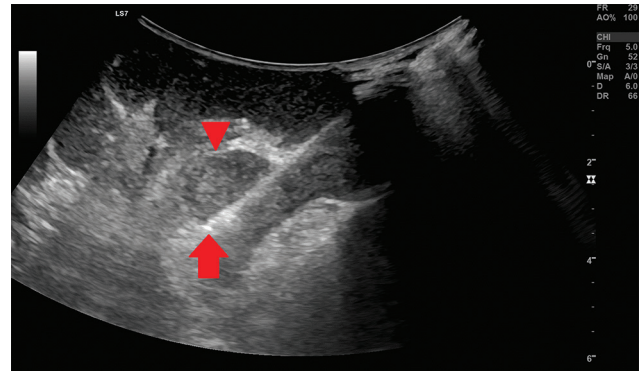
Intraoperative ultrasound directly onto the renal capsule shows the ablation probe placed (arrow) within the mass (arrowhead).
